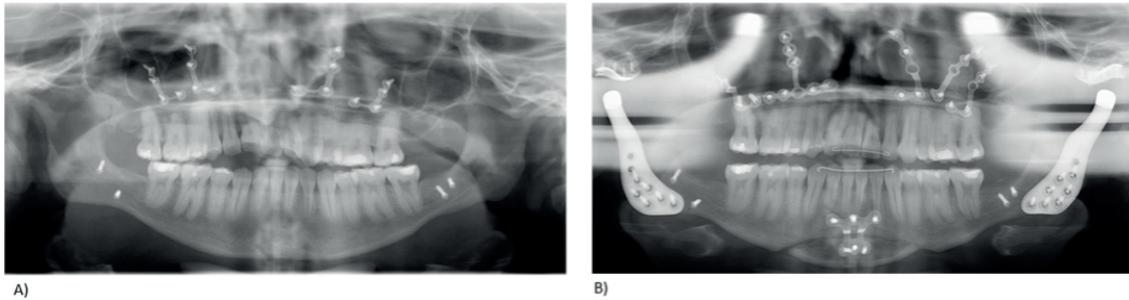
(a) Preoperative panoramic radiograph showing bilateral condylar head changes and retained bone plates and screws from previous orthognathic surgery. (b) Postoperative panoramic radiograph.
